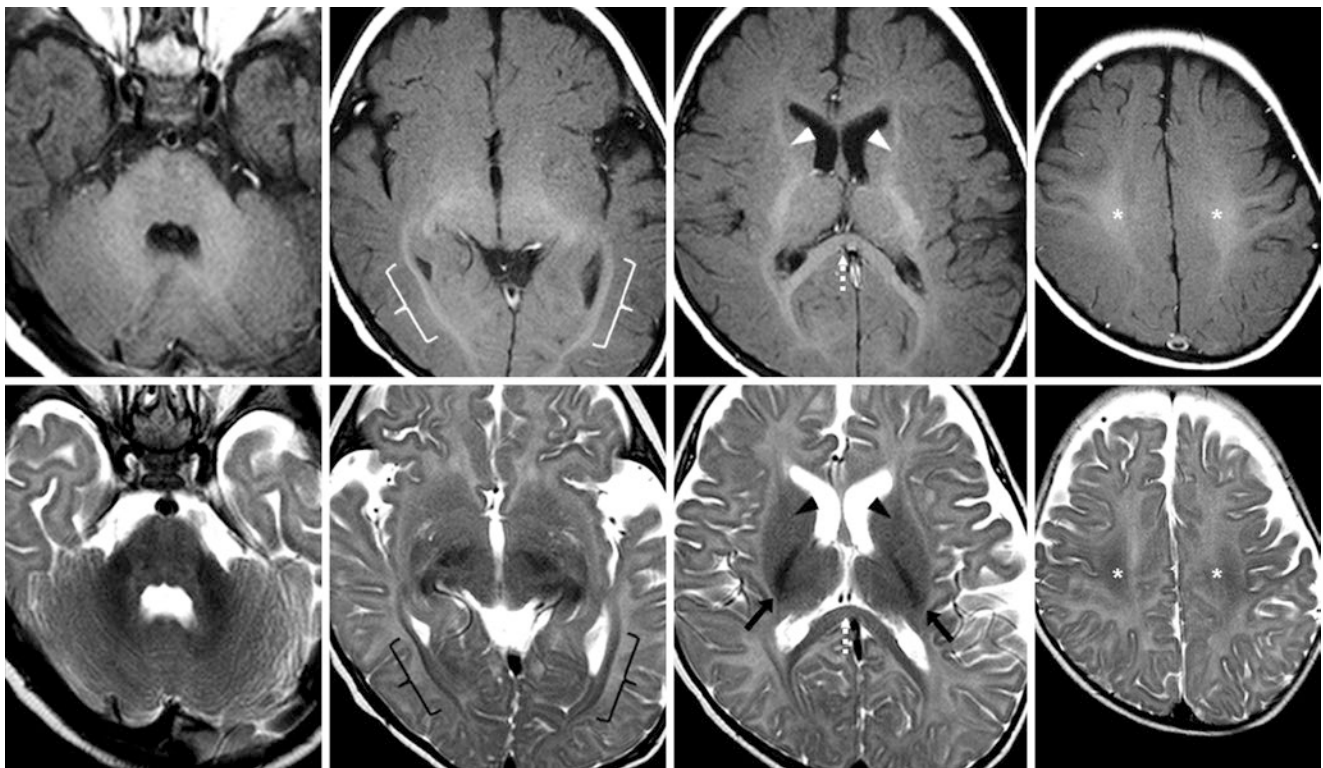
A 16-week-old with head enlargement (benign enlargement of subarachnoid spaces) had a negative 3T MRI with GE T1WIs (*top row*) and SE T2WIs (*bottom row*). The pons is homogeneous in signal. Myelination of cerebellar white matter appears complete. The
